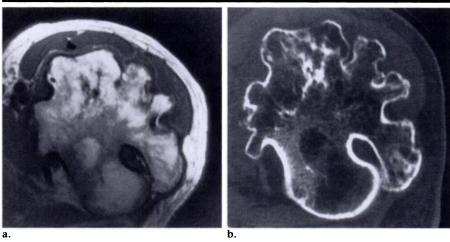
Osteochondroma. (a) Axial T1-weighted MR image (SE 700/11). (b) CT image. Both the MR and the CT images show that the lesion is contiguous with the medullary cavity of the proximal femur and contains normal-appearing trabeculae and fat. The cartilage cap is very thin and difficult to see with either modality.
